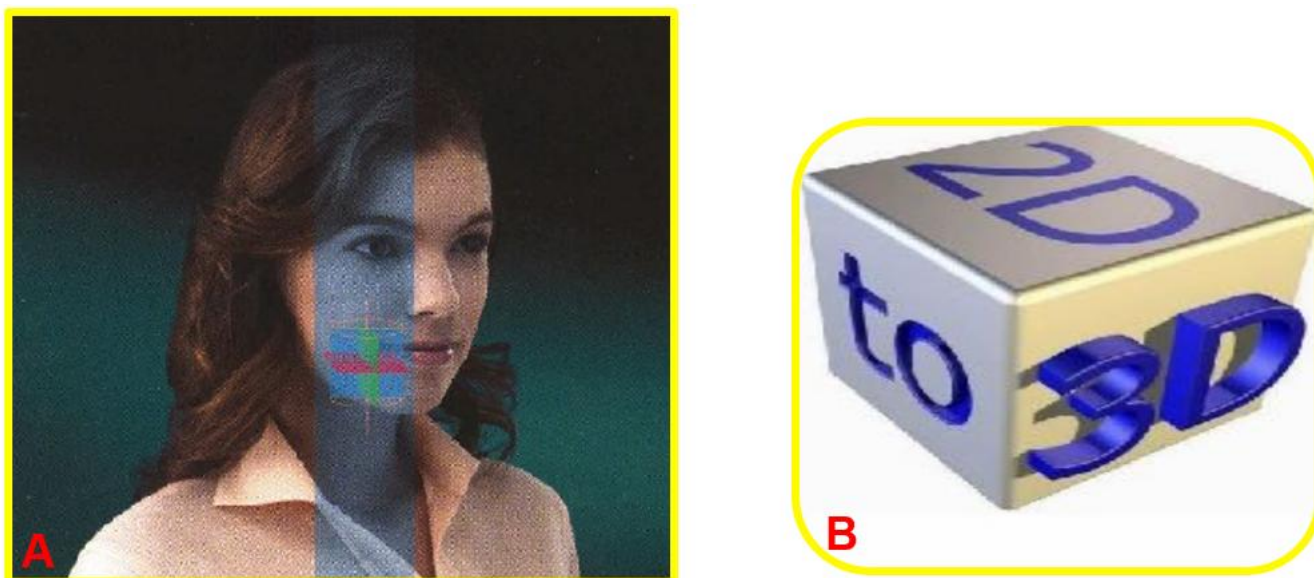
CBCT has the ability to capture, store, and present radiographic images in various horizontal and vertical planes (A,B).
